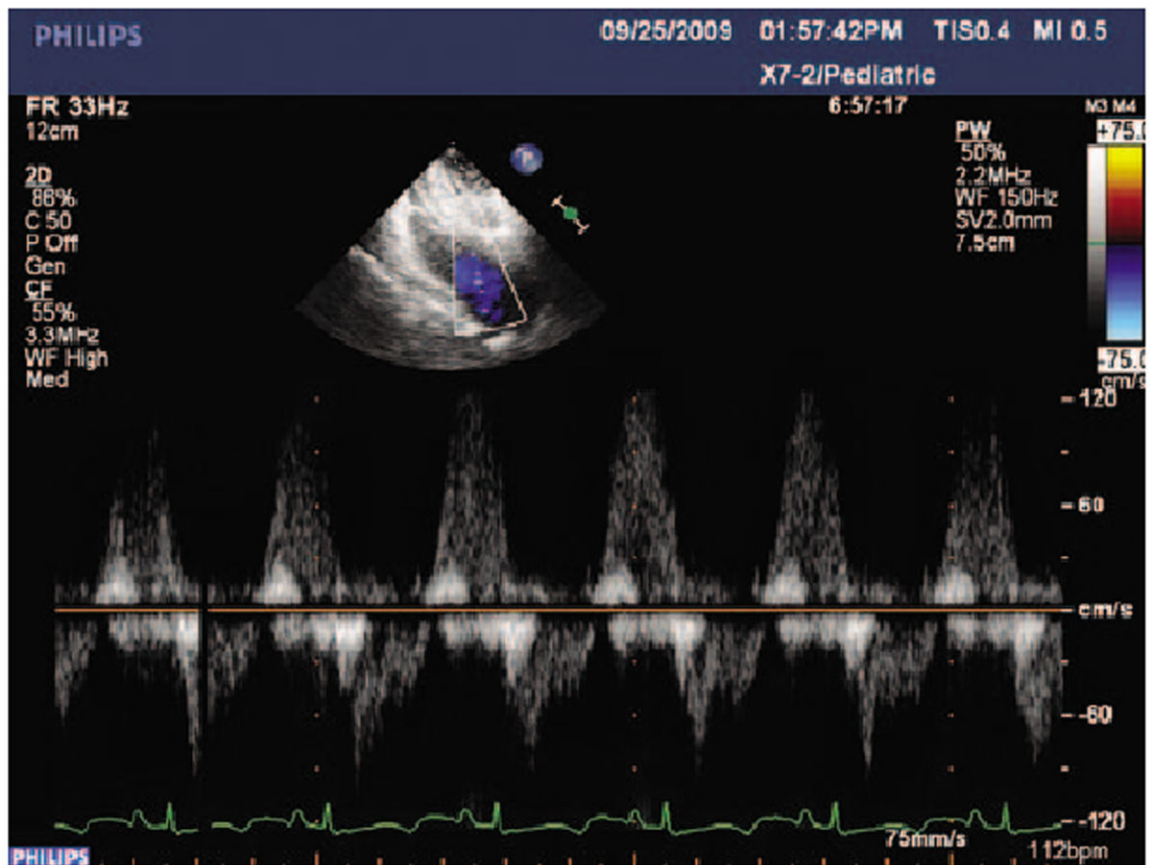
Post-valvectomy pulsed-wave Doppler echocardiographic study demonstrating regurgitant flow in the RVOT at the level of the pulmonary annulus.
